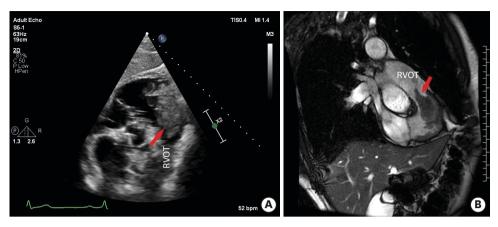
(A) Subcostal short axis view on transthoracic echocardiogram showed the right ventricular mass prolapsing into pulmonary artery during systole. (B) T1-weighted images showed that the mass is isointense (red arrow). RVOT: right ventricular outflow tract.
